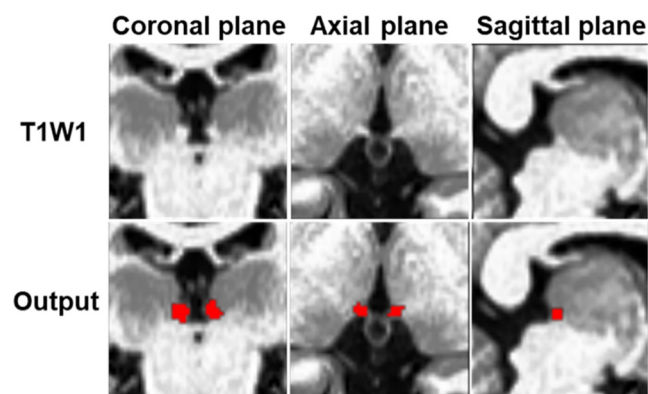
Habenula segmentation. The upper panels show a T1-weighted image, while the lower panels show the output from the prediction model for habenula segmentation
